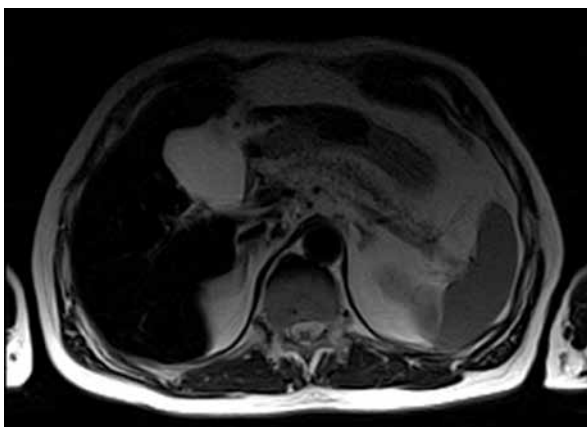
Magnetic resonance imaging scan of the iron overloaded liver
